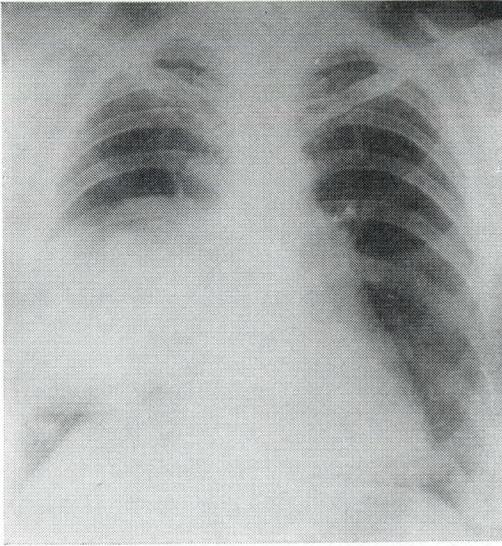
Case 5—malignant teratoid cyst. Pre-operative chest radiograph.
